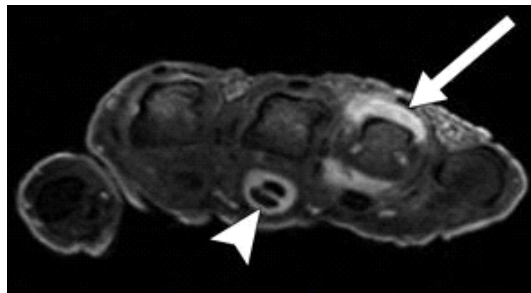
MRI showing florid synovitis at fourth MCP joint
